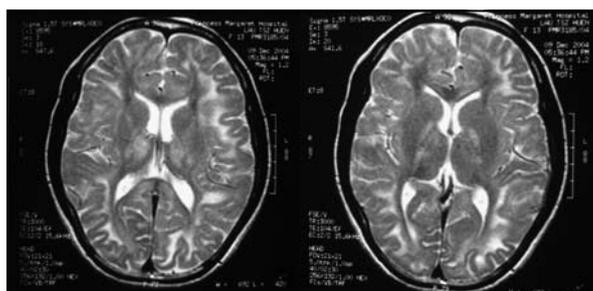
Magnetic resonance imaging of the brain showing bilateral, extensive and symmetrical areas with signal changes involving cerebral white matter, deep cerebellar white matter and deep grey matter
